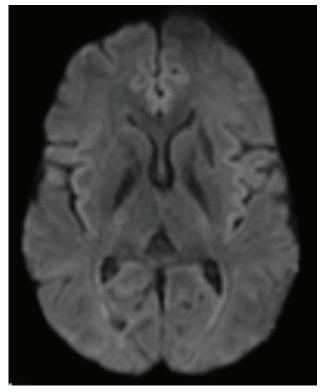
DWI (Diffusion Weighted Imaging) sequence showing no abnormalities
